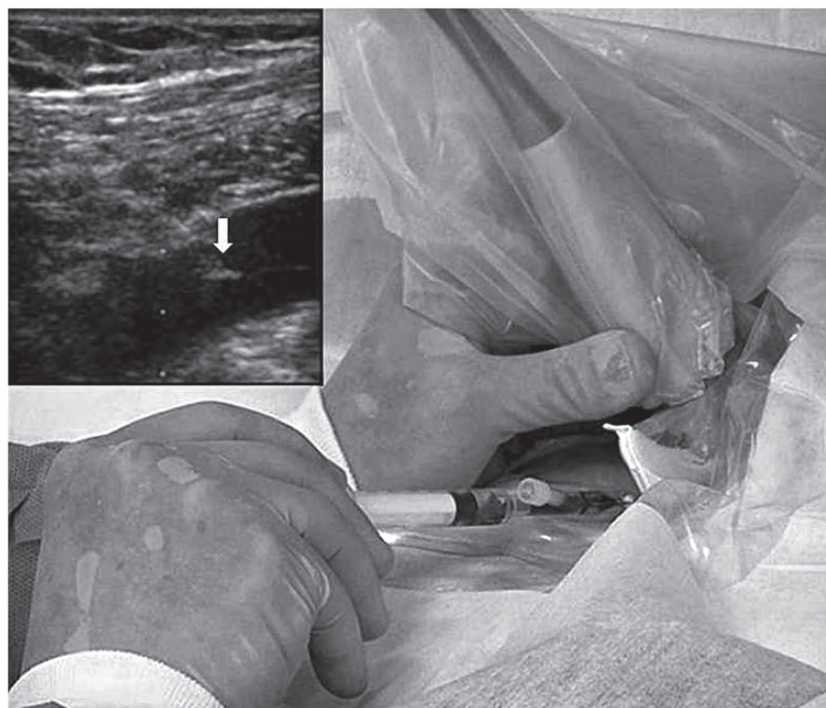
Real-time ultrasound-guided central venous catheterization. A needle has been introduced into the infraclavicular axillary vein utilizing ultrasound guidance with a needle guide controlling the passage of the needle in an in-plane approach. Inset: the needle tip is seen within the vein (arrow).
